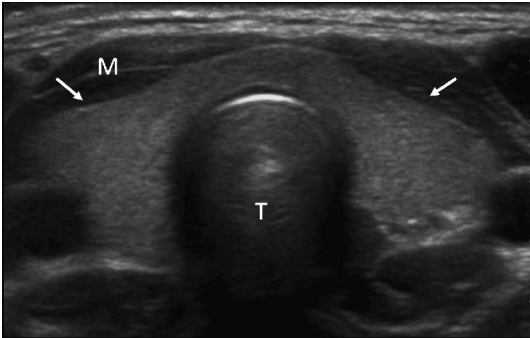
Normal sonographic appearance of the thyroid. The thyroid (*arrows*) sits atop the trachea (T) and is a bilobed structure echogenic to the adjacent musculature (M).
